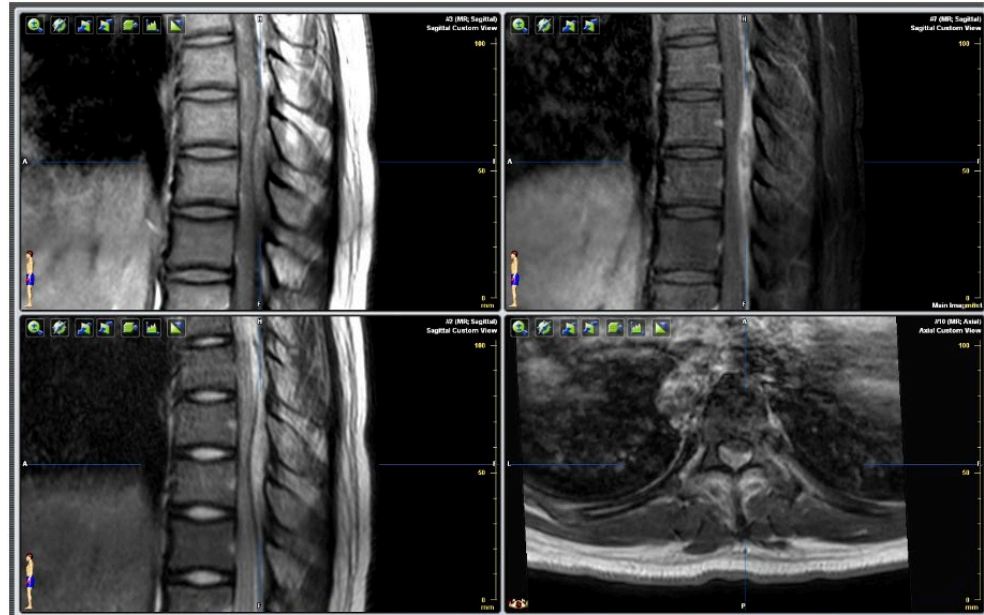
MRI spine taken on day 1 presentation, showing T8-10 extradural lesion with peripheral enhancement and central hypoenhancing area, exhibiting T1 intermediate and T2 hyperintense signal.
